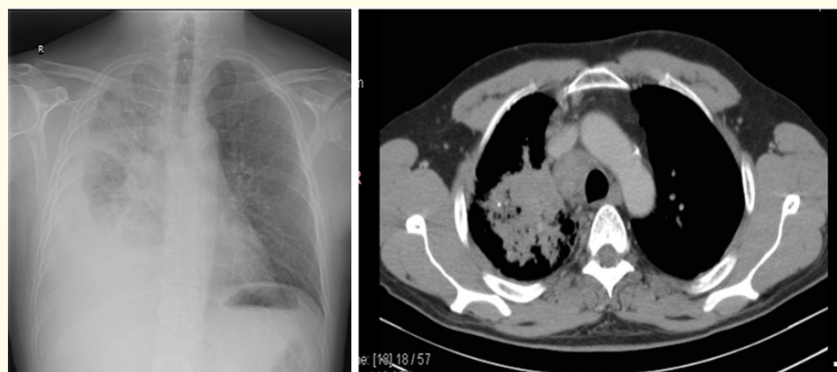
Chest X-ray (CXR) and computed tomography (CT): A right upper lobe lung mass, mediastinal lymphadenopathy and a free-floating, right medium-sized pleural effusion.
